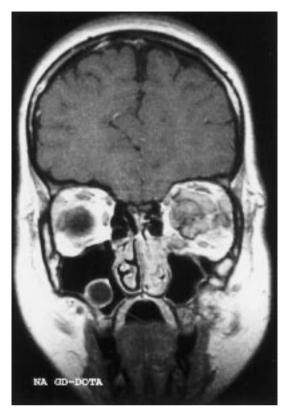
$\mbox{MRI-T}_1$ after gadolinium: shows the absence of contrast enhancement
